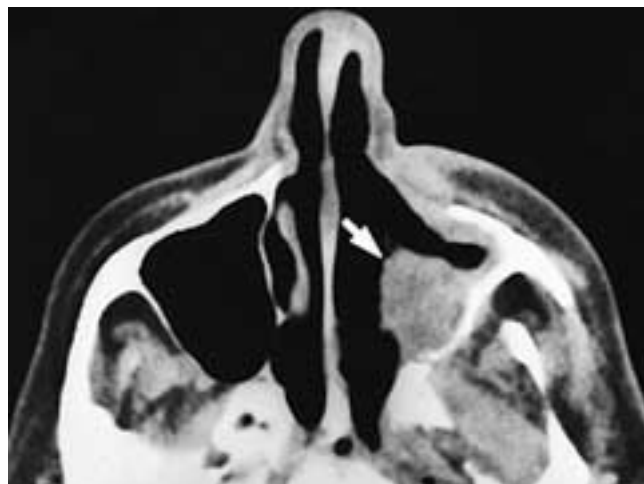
Axial CT scan on a patient after partial left maxillectomy with irregularly nodular tumor recurrence (*arrow*) in the antrum. The smooth soft tissues lining the anterior left antrum were scar tissue.
